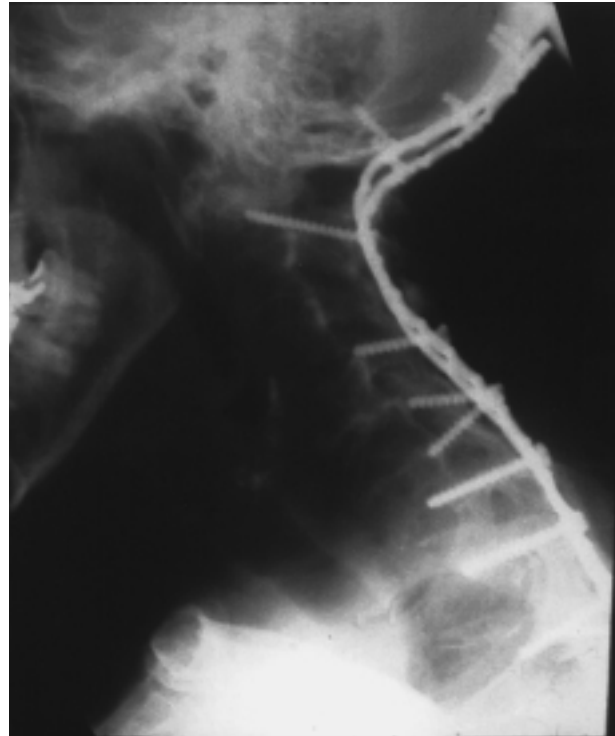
Lateral radiograph of a patient with occipitocervical fusion for rheumatoid neck disease.
